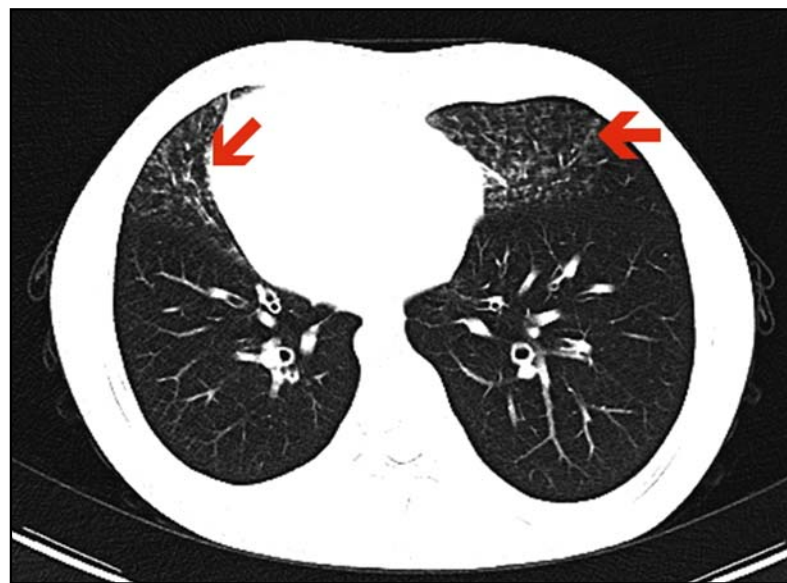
Chest CT (Hebei General Hospital, September 14, 2019)
